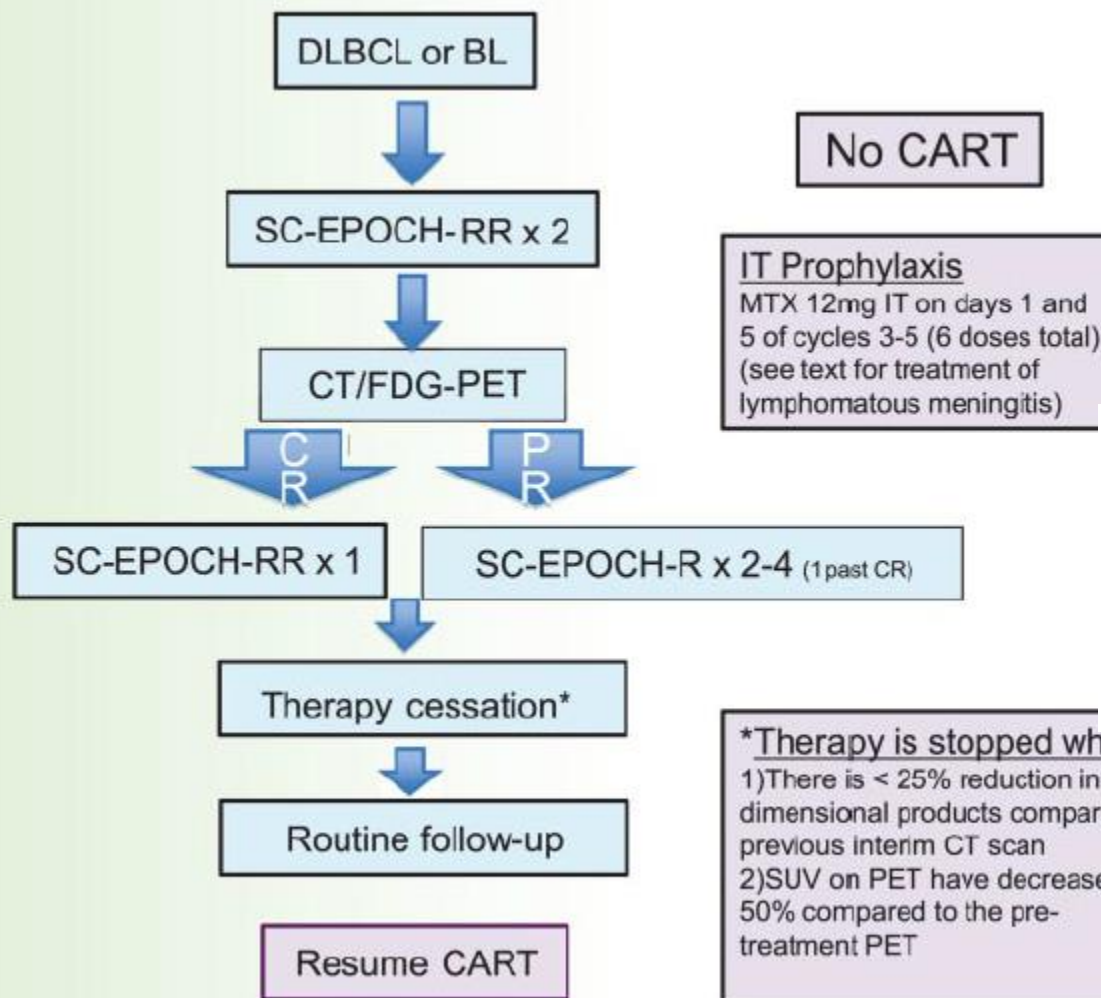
SC-EPOCH-RR treatment paradigm. Patients receive 2 cycles of SC-EPOCH-RR and are then restaged by CT and FDG-PET scanning. Patients in CR after 2 cycles receive one more cycle (minimum 3) of therapy. Patients with a "positive" CT and/or FDG-PET study after 2 cycles receive additional cycles until they were negative, for a maximum of 6 cycles.
